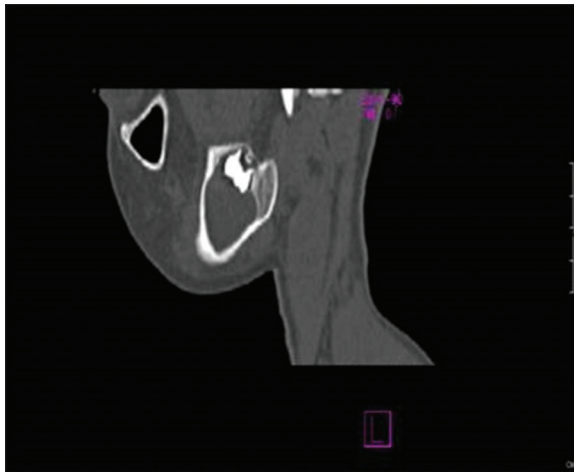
Sagittal computed tomography section showing hypodense area surrounding the developing tooth bud of 47
